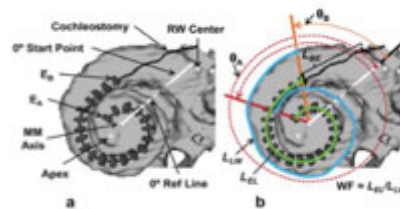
CT derived images of a participant's electrode array (Contour Advance) and corresponding markers used to measure array position (Holden et al. 2013)
